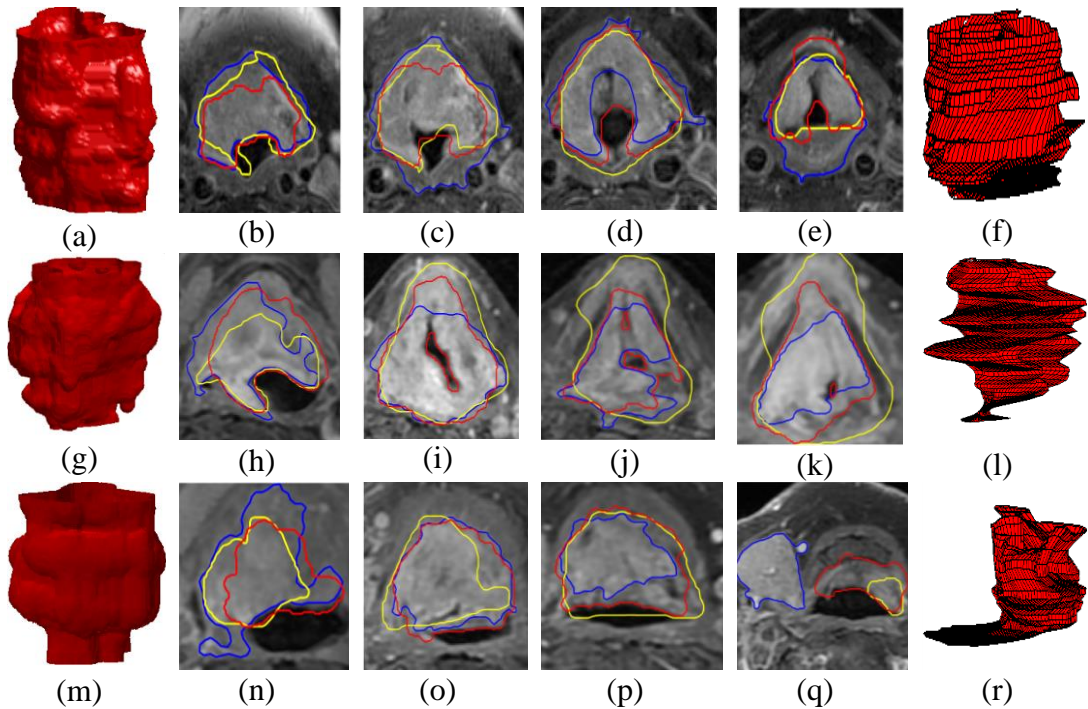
3D tumour volume segmented from real MRI data each row uses the same dataset. (a)(MR11092012) (g) (27082012) ((m) (MR10062013) are volumes obtained by proposed algorithm; (f)(l)(r) are volume acquired by 2D method; (b)(c)(d)(e), (h)(i)(j)(k) and (n)(o)(p)(q) are 2D contours on separate axial slices. Yellow contours are from gold standards (consensus manual outline), red contours are from proposed algorithm, and blue contours are from 2D approach [193].
